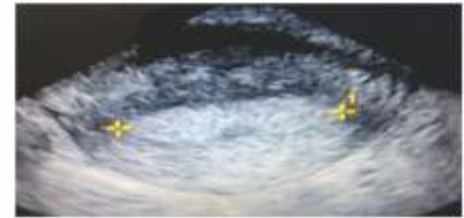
B mode ultrasound showing transverse section of uterus measuring endometrial length in transverse section
